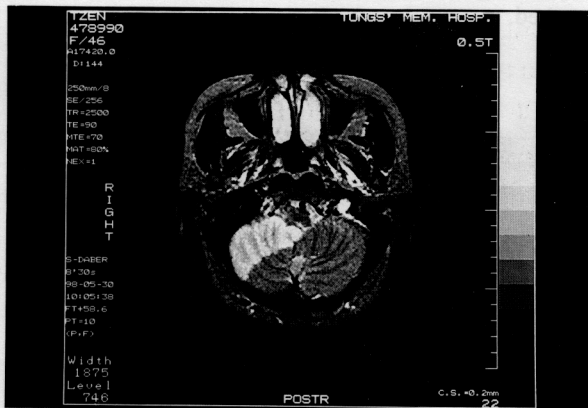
Axial view: T2-weighted image of MRI reveals an infarction of the right anterior inferior area of the cerebellum.
